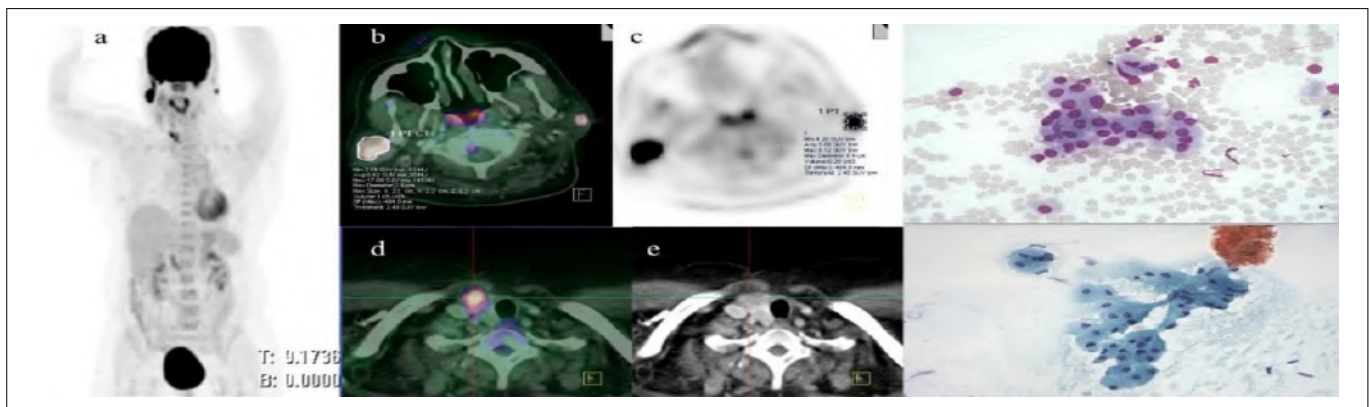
^{18}F -fluorodeoxy-D-glucose positron emission tomography/computed tomography incorrectly diagnosed as malignancy of parotid in this 60-year-old woman who presented with progressively increasing parotid swelling for a duration of six months. The final diagnosis was Birt-Hogg-Dubé syndrome with benign oncocytoma of the parotid.
